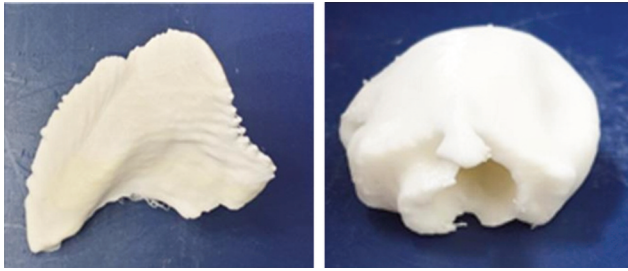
Customized 3D bolus for (a) patient 1 and (b) patient 2. The 3D bolus in (a) is generated from the extended tumor in CT of patient 1 to provide a sufficient dose to the tumor located in the shallow area of the skin. (b) The 3D bolus of a 50 ml balloon inserted into the mouth patient 2 during CT scan. An air cavity was created in the middle of the bolus for the patient to breathe comfortably.
